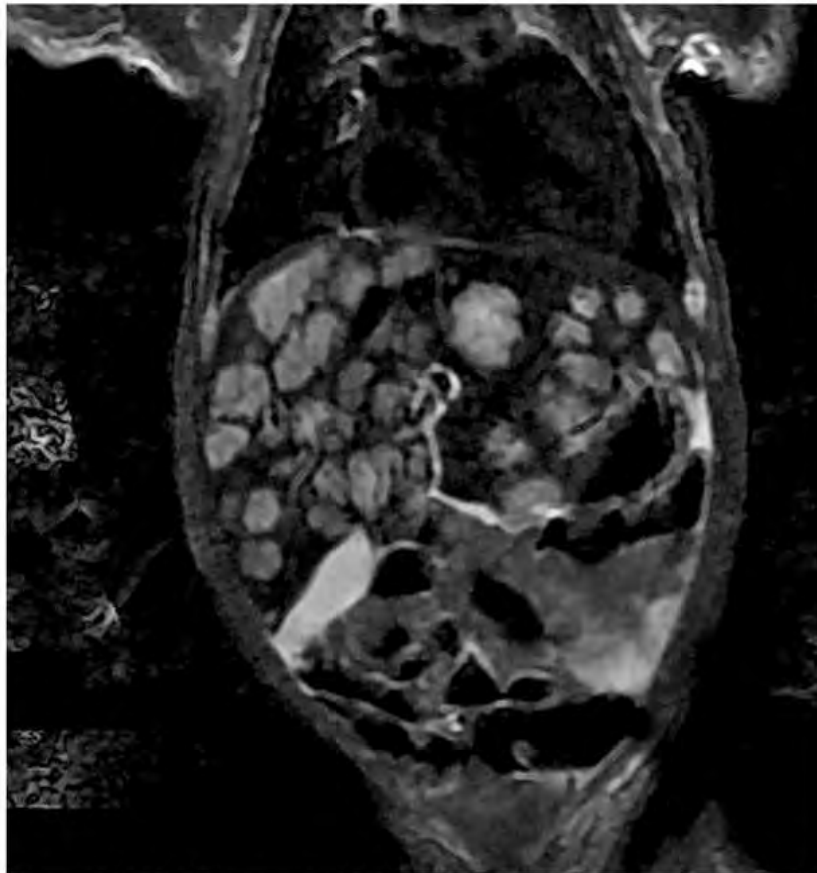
MRI delineates multiple discrete homogeneous lesions, 10-30 mm in diameter with very little liver parenchymal between them.
